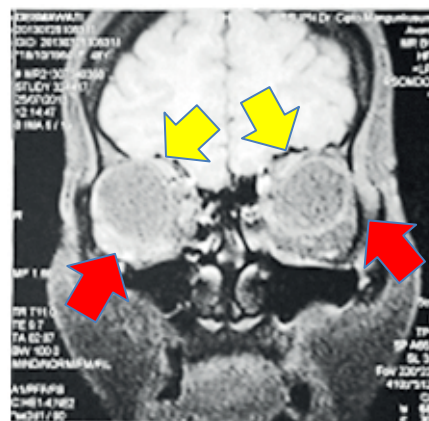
Orbital MRI revealed medial displacement of SR (yellow/upper row arrows) and inferior displacement of LR (red/lower row arrows) of both eyes
